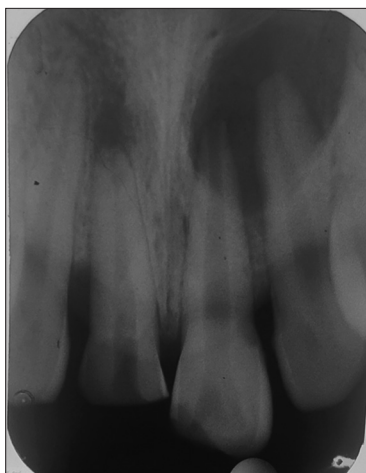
Pre-operative radiograph showing immature apex irt 21
